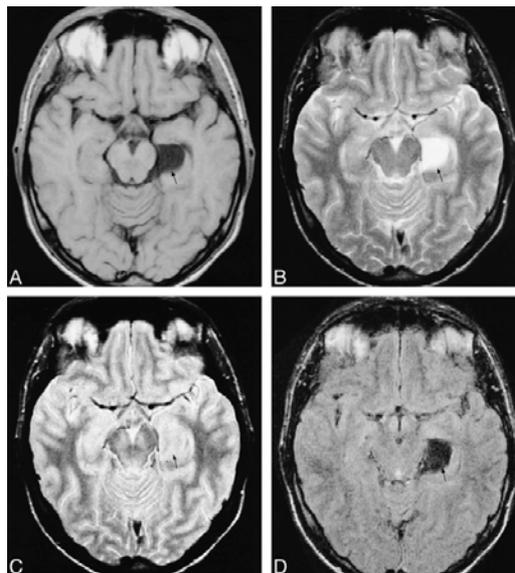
Conventional MR image slices.(a)T1-weighted (b) T2 – weighted (c) PD weighted (d) FLAIR [4]
